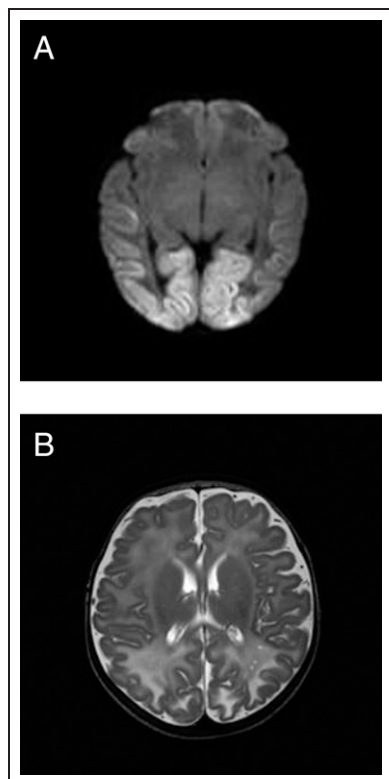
Brain MRI from a 4-day-old infant who experienced profound hypoglycemia. Note the restricted diffusion in the bilateral occipital and posterior parietal regions that can be seen with ischemia and severe hypoglycemia. B. Repeat MRI of same patient at age 6 weeks. Note the T2 hyperintensity in the bilateral occipital lobes consistent with gliosis from previous injury. There is also occipital lobe cystic encephalomalacia.
